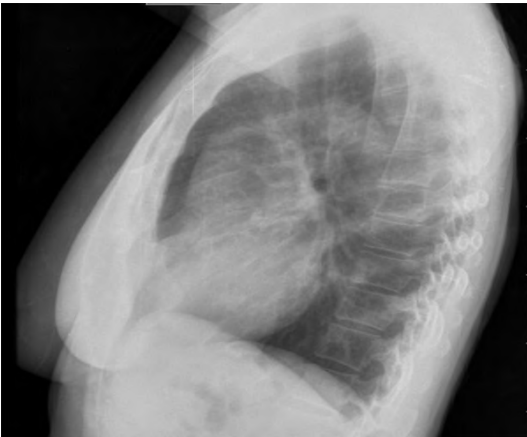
Chest x-ray image in profile, UFU Medical School Clinics Hospital, Brazil, 2021.
